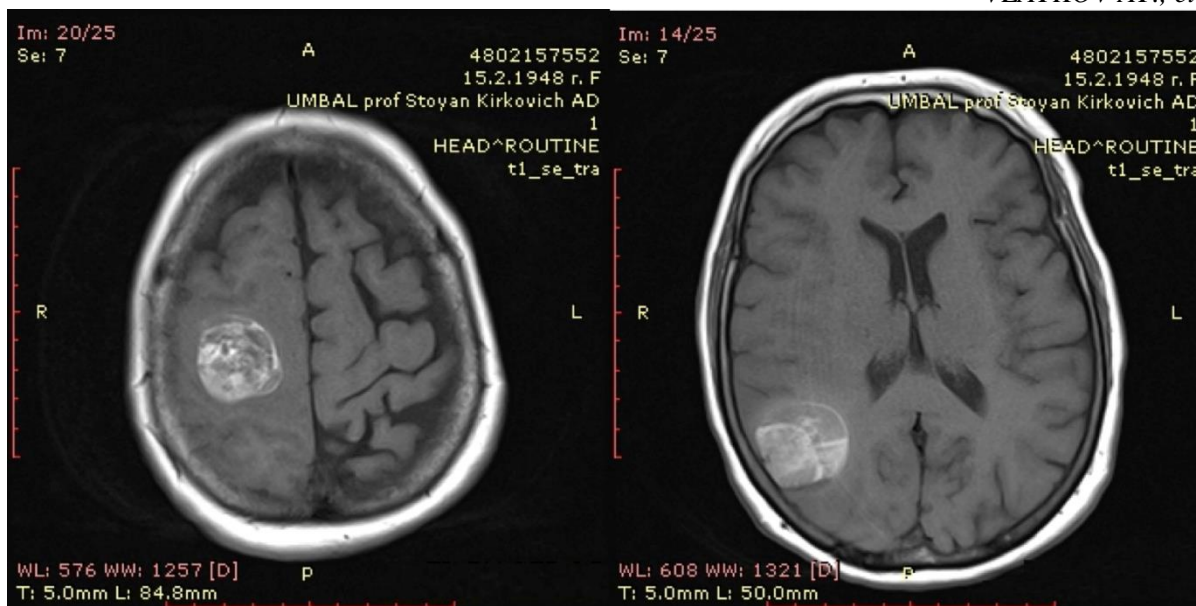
CT scan demonstrates brain metastases
